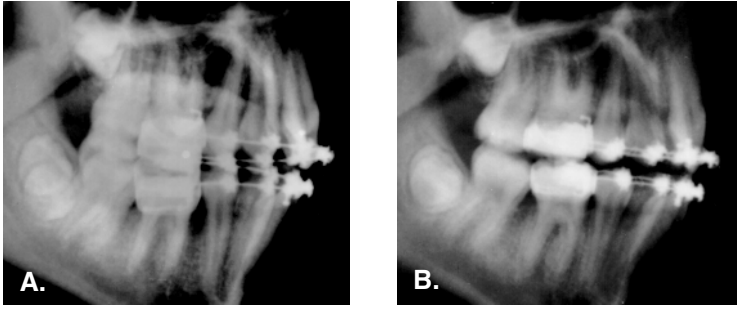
A&B. A) Lateral head X-ray taken at the start of stage three. Rectangular wires, .0215" x .028", in both arches and Side-Winder springs in place to provide both crown tip and torque forces. B) Lateral head film taken seven months later. Note little, if any, change in the labiolingual inclination of maxillary anterior teeth yet the first premolars have uprighted.
